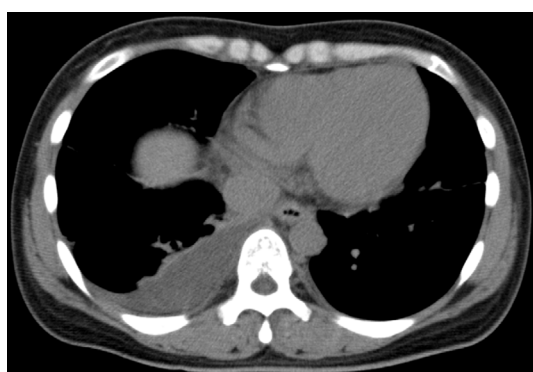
Chest computed tomography (CT) findings on admission. There was pleural effusion in the lower lobe of the right lung.
